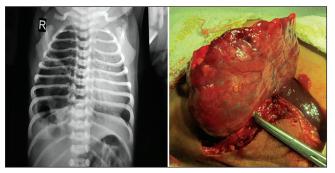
X-ray chest PA view showing right congenital cystadenomatoid malformation with intra-operative excision
